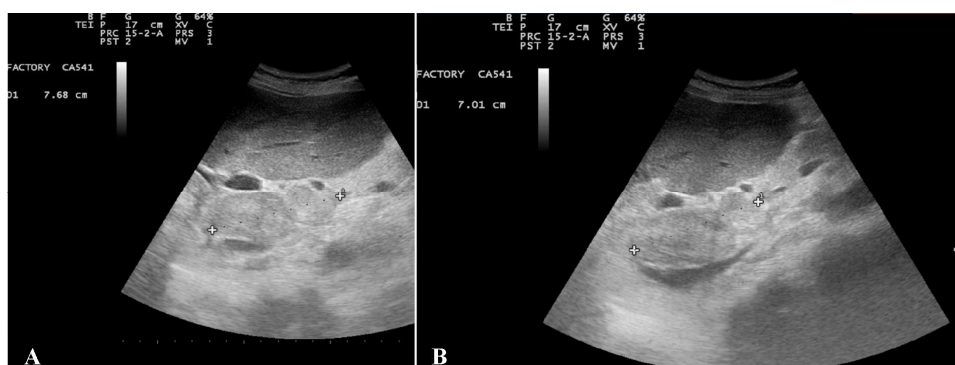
Ultrasonography of abdominal metastasis. A 55-year-old woman was diagnosed with metastatic adenocarcinoma of the colon. After 3 weeks of integrative immunotherapy where OA-GcMAF (880 ng/day) was administered by alternating nebulisation, intramuscular injections and suppositories, one of the lesions in the abdomen, interpreted as one of the metastases previously described, measured with ultrasonography, showed a decrease of its length from 76.8 mm (panel A) to 70.1 mm (panel B). This corresponds to an approximate 9% linear diameter reduction. In this case the volume could not be fully extrapolated since the mass showed an irregular elongated shape
